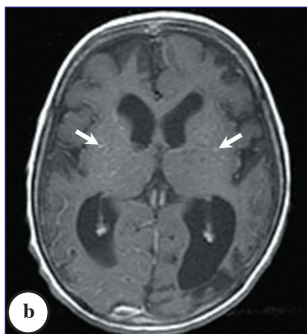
a) Axial T2-weighted image of the brain showing left temporo-occipital cortical high signal due to infarction and multiple signal voids due to dilated collaterals in the basal cisterns. b) Enhanced axial T1-weighted image showing enhanced dilated basal collateral channels (arrows). c & d) MR angiography showing severely attenuated caliber of distal parts of both internal carotid arteries (open arrows), dilated collaterals (solid arrows), and normal caliber of posterior cerebral arteries.
